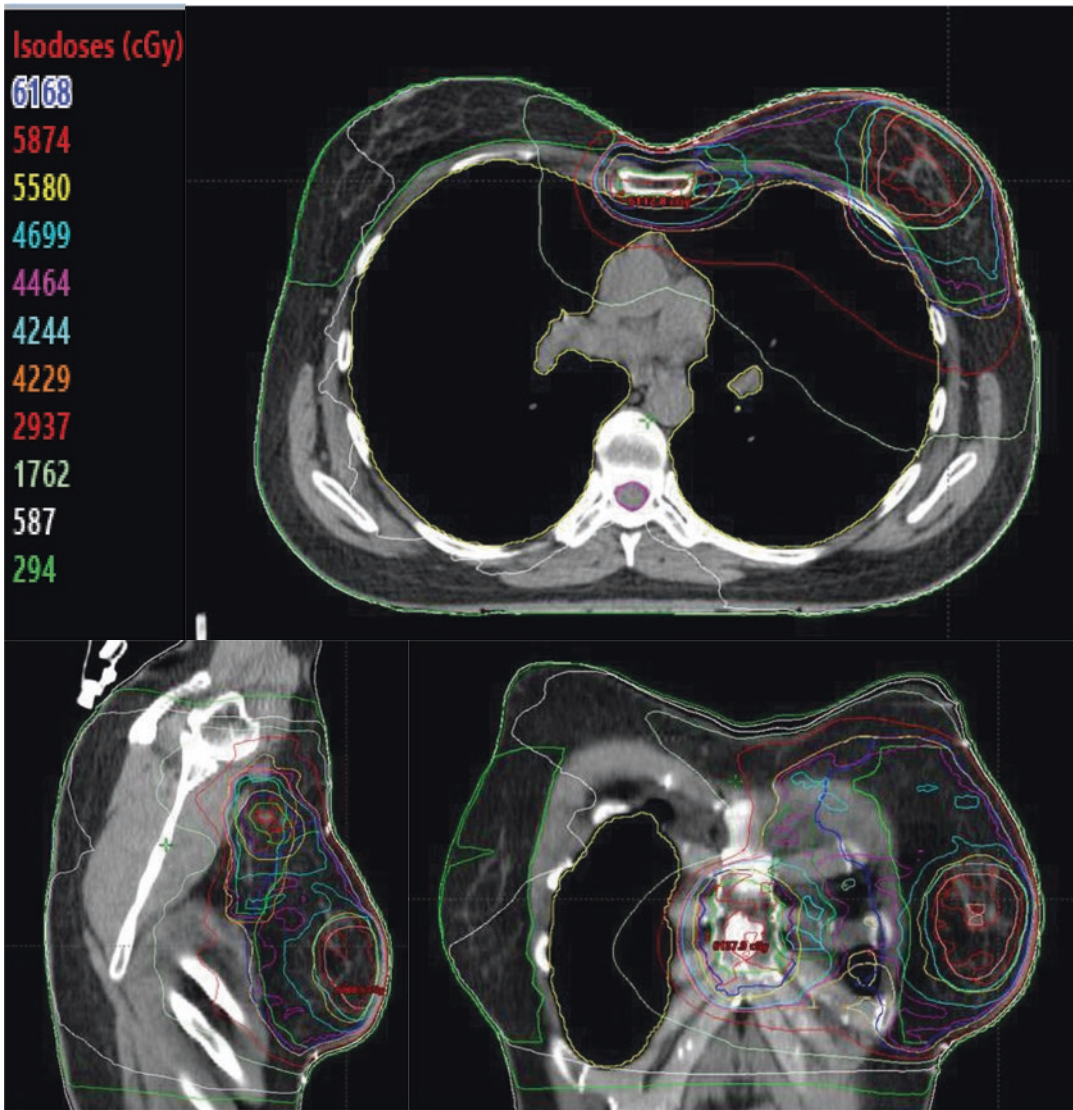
Radiation planning CT showing the dosimetric distribution
